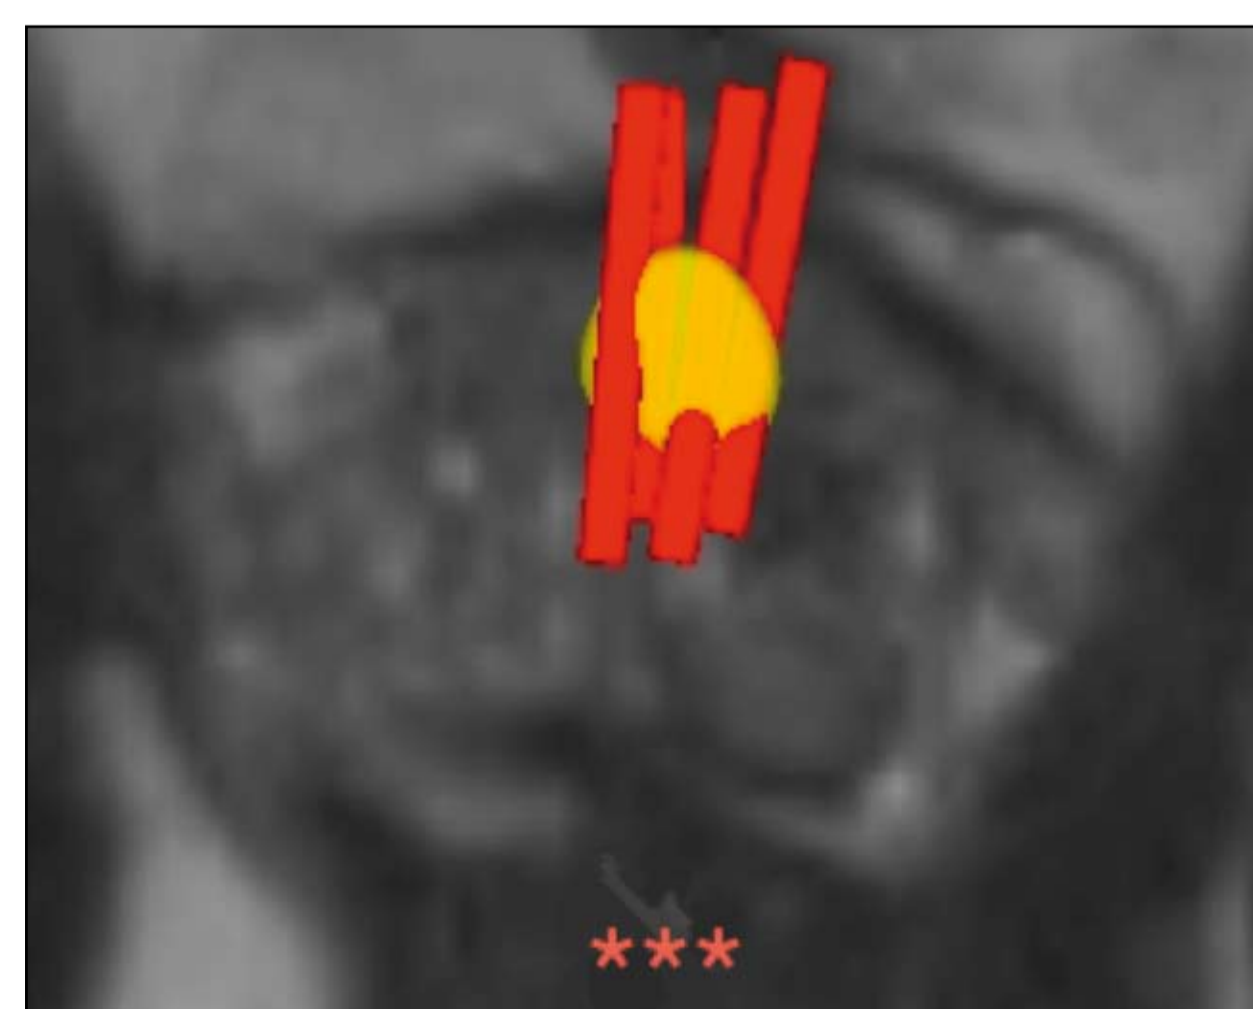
Axial and sagittal images as displayed in the Urostation when performing targeted biopsies. The four red bars represent the biopsy needle tracts, all within the MRI target (yellow circle). All cores were positive for prostate cancer Gleason score 7a.
